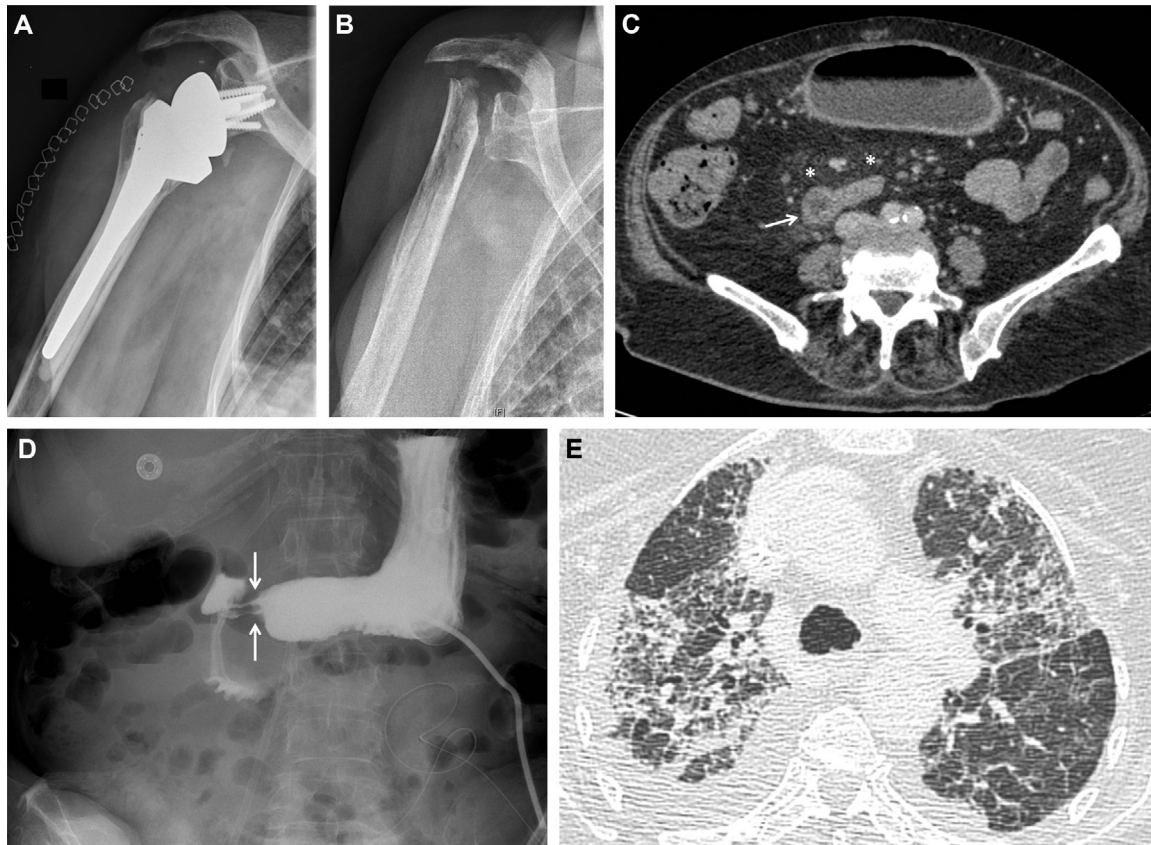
Morphological investigations. A. Standard X-ray of the right shoulder showing classical reverse shoulder prosthesis just after implantation. B. Standard X-ray of the right shoulder after prosthesis removal for *Mycobacterium bovis* chronic prosthetic joint infection. C. Abdomen CT-scan showing duodenojejunal wall thickening (arrow) with fatty infiltration of the mesentery (asterisk). D. X-ray after barium swallow confirming duodenojejunal stenosis secondary to a non-necrotizing granulomatous duodenojejunitis (arrows). E. Thoracic CT-scan (panel E) revealing diffuse pulmonary fibrosis secondary to diffuse alveolar damage and *M. bovis* infection.
